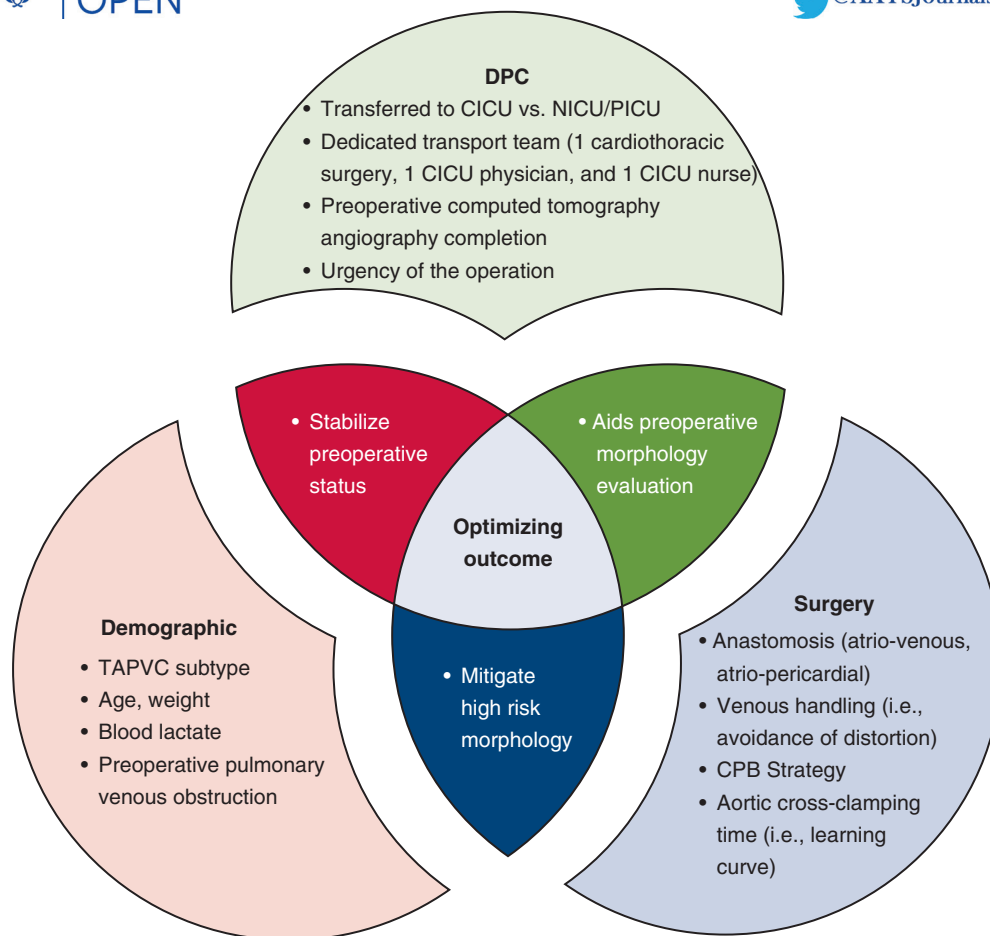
Patient demographics, surgical techniques, and DPC are 3 predictors for outcomes after neoTAPVC surgery. DPC is helpful for stabilization of patient preoperative status, and allows preoperative CTA, which aids individual morphologic evaluation. *DPC*, Dedicated presurgical care; *CICU*, cardiac intensive care unit; *NICU*, neonatal intensive care unit; *PICU*, pediatric intensive care unit; *CPB*, cardiopulmonary bypass; *TAPVC*, total anomalous pulmonary venous connection; *neoTAPVC*, neonatal total anomalous pulmonary venous connection; *CTA*, computed tomography angiography.
